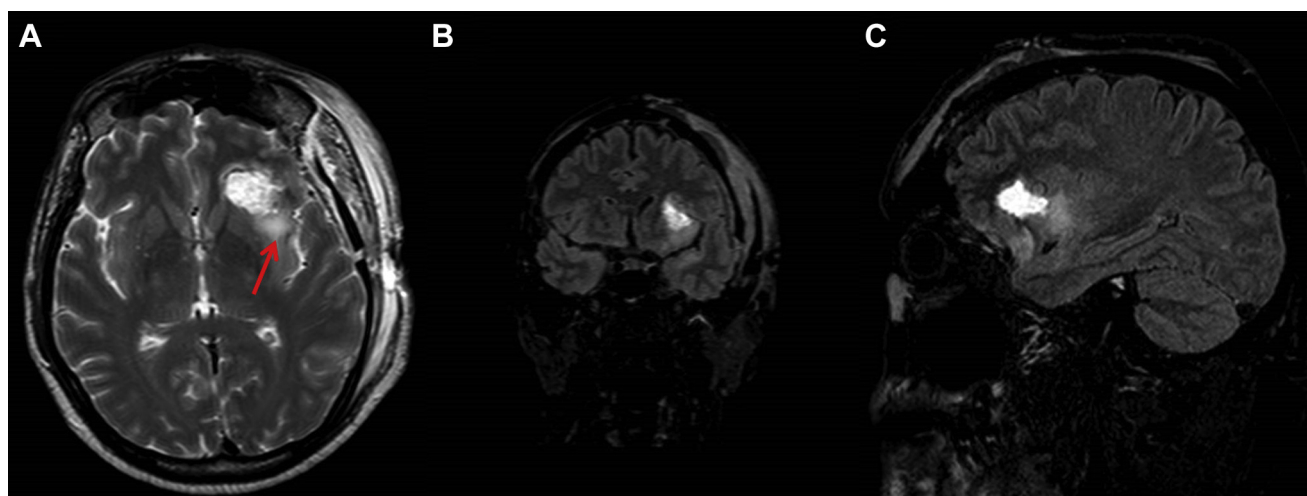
Case 1. Postoperative T2-weighted axial (A), T2-fluid-attenuated inversion recovery coronal (B), and sagittal (C) magnetic resonance imaging
